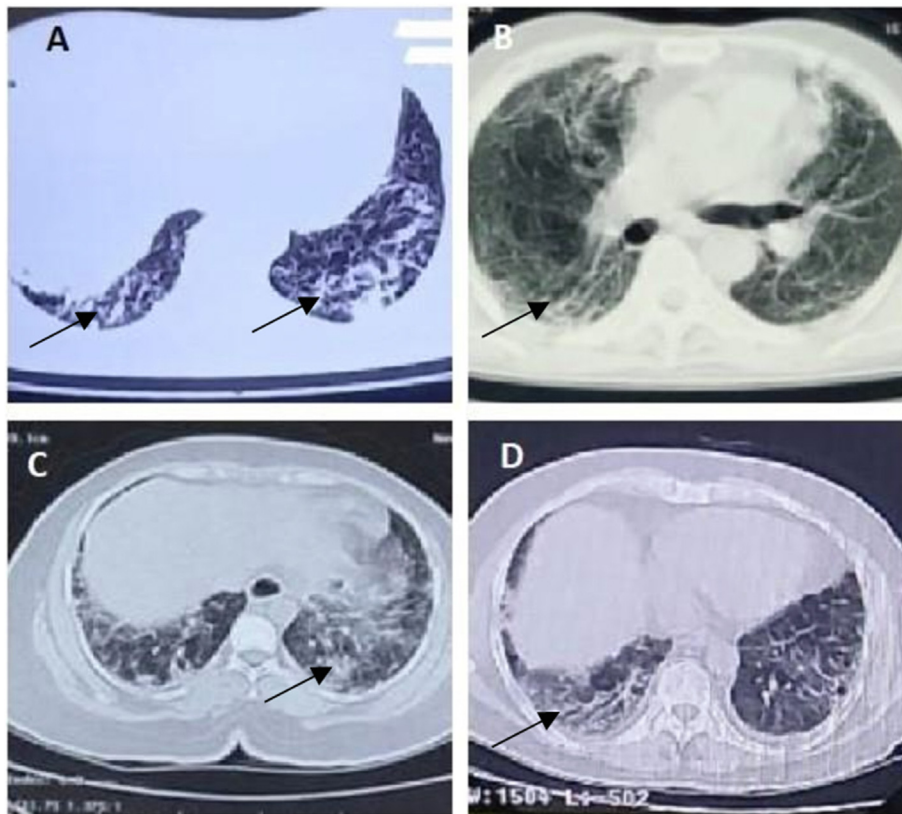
A: Case 1, B: Case 2, C: Case 3, D: Case 4. (A–D) Images of HRCT thorax showing areas of fibrosis, involving the lower lobes with dominant subpleural pattern of distribution (marked with black arrow).
